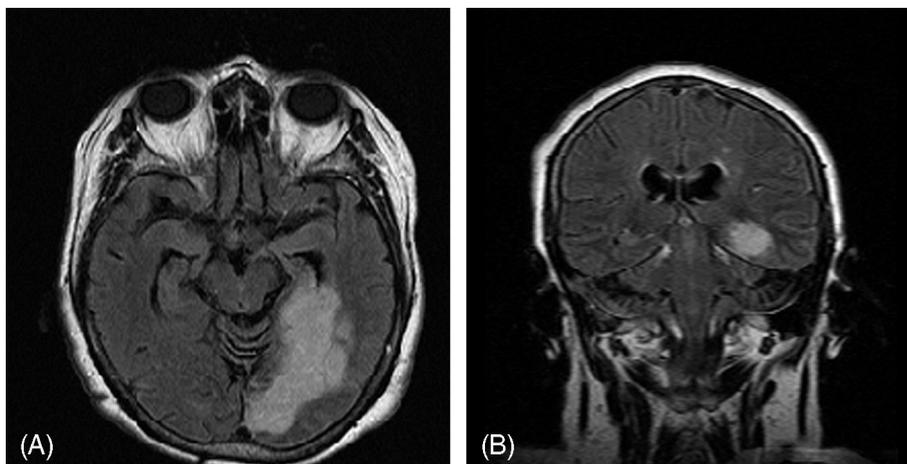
MRI scan (A, B) showing a cortical left-sided posterior cerebral artery territory infarct. Note the involvement of the medial part of the temporal lobe on the coronal sequence (B), in contrast to Fig. 22.8.
